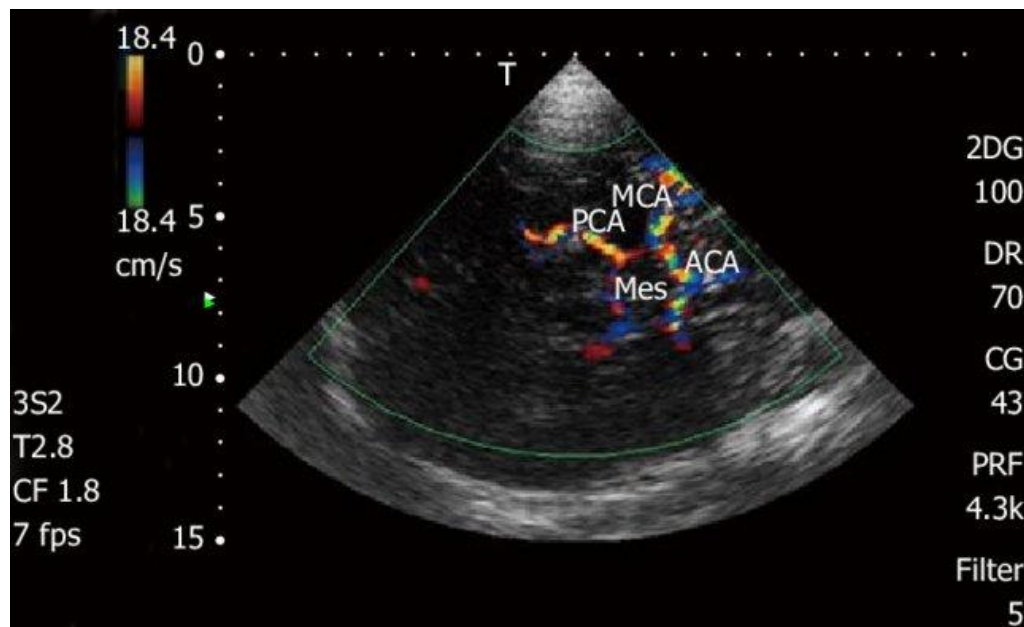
Transcranial Doppler color: Doppler study of intracranial arteries (10).
